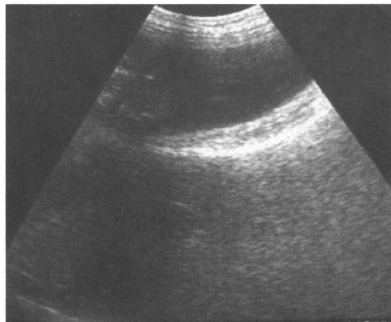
A case of hemoperitoneum. Hemoperitoneum was diagnosed based on an intra-abdominal echo-free space on ultrasonography.
